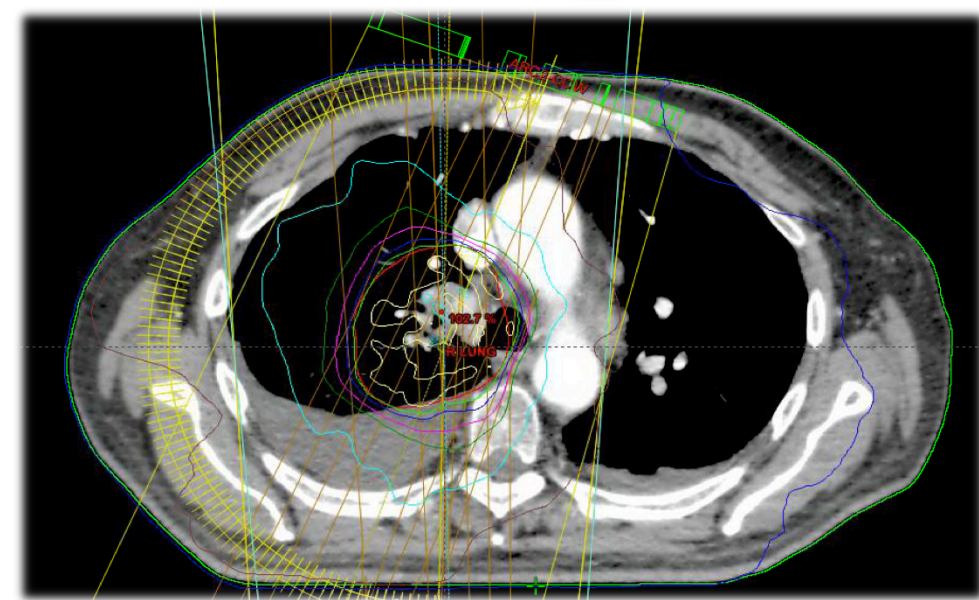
Treatment plan for a lung patient, lung collapsed at time of planning CT scan
